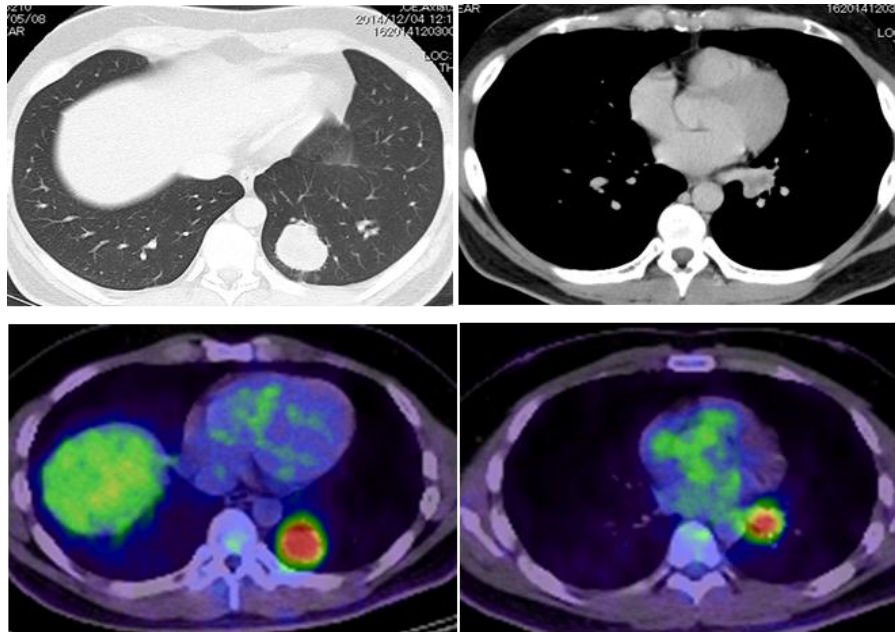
Chest computed tomography (CT) and positron emission tomography (PET) suggested a primary lung tumor in the left lower lobe and left hilar lymph node metastasis.
